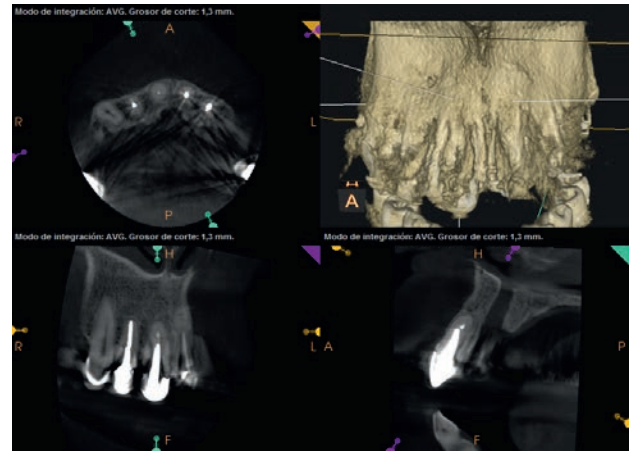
18 months control CBCT image of upper right central incisor after periapical microsurgery, showing complete healing of the previous periapical radiolucent lesion.
